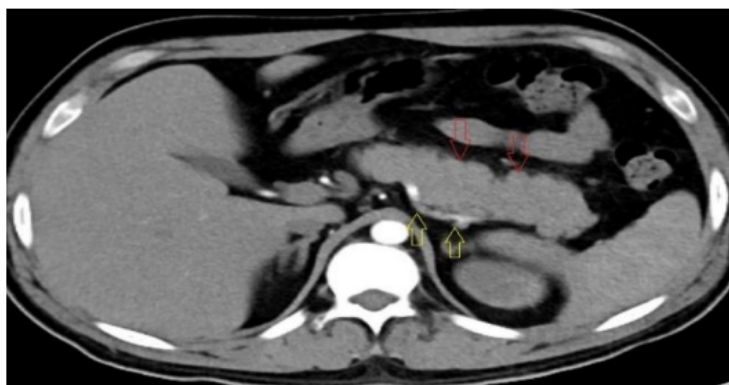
Contrast enhanced CT scan was done after 72 hours which showed focal pancreatic body and tail enlargement with surrounding retroperitoneal fat stranding (2.7 x 3.9 x 1.5cm)
